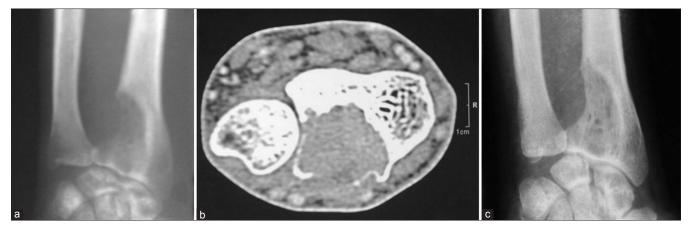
Preoperative X-ray anteroposterior view and computed tomography scan (a and b) showing GCT distal radius (c) postoperative radiograph after 2 years demonstrating the smoothening the wall of cavity and good supporting sub-chondral bone with no arthritic changes and no recurrence
